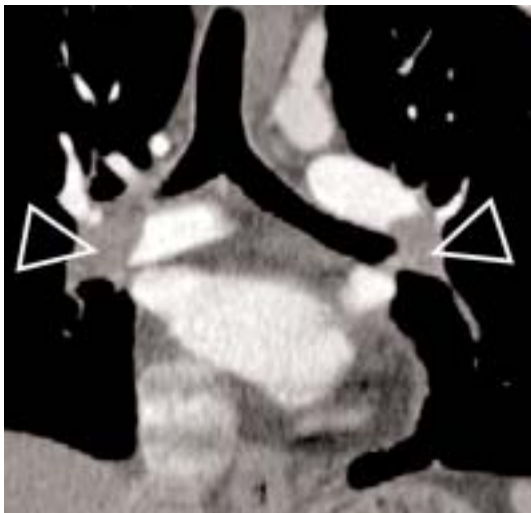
2B. A 16-row multidetector computed tomography angiography of the pulmonary circulation was obtained. Coronal (Figure 2A) and transverse (Figure 2B) reconstructions show homogeneous enhancement of the pulmonary arteries. Central massive emboli are displayed in the left and right main pulmonary arteries (arrowheads).
